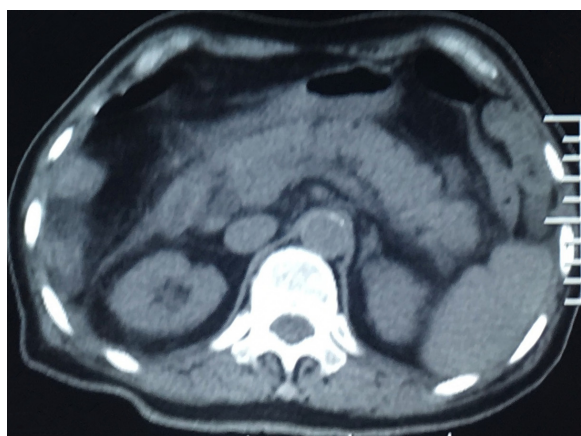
Abdominal CT was performed at a local hospital on March 2018 and showed abnormal morphology of the pancreas.
